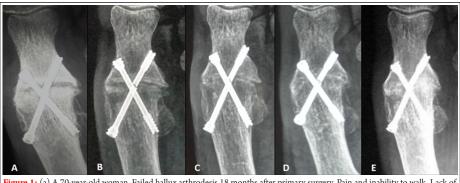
(a) A 70-year-old woman. Failed hallux arthrodesis 18 months after primary surgery. Pain and inability to walk. Lack of union is observed and the medial screw has suffered material fatigue. The option is surgical. (b) Two months after the application of three sessions of high energy focused shock waves. (c) Three months after shockwaves. (d). Four months after shockwaves. Arthrodesis has been completed and the patient is asymptomatic with no pain on gait. (e) Radiographic control at 2 years.
